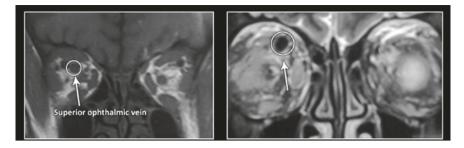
In MRI, the diameter of the superior ophthalmic vein is notably enlarged and dilated
